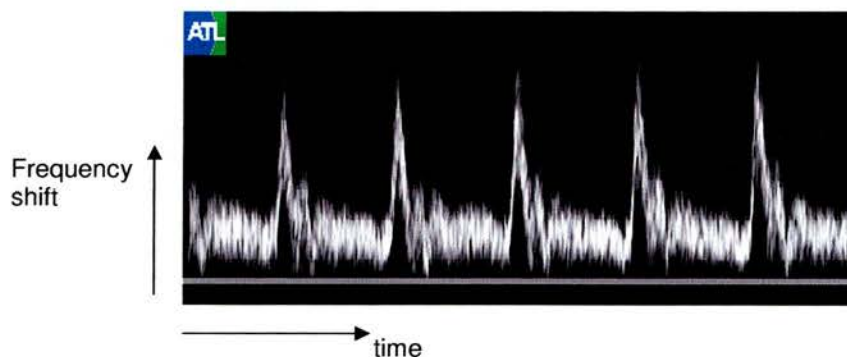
Spectral Doppler trace of an asymptomatic common carotid artery.
